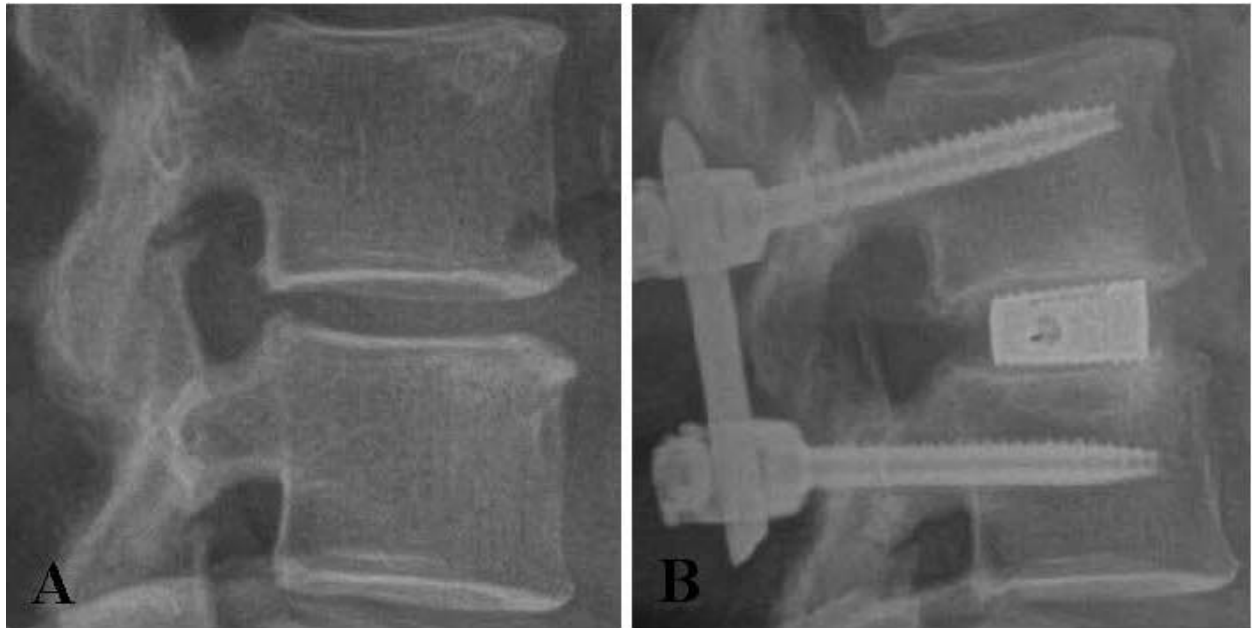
Representative (A) preoperative and (B) 12-month postoperative lateral plain film radiographic images of a 64-year-old female who underwent LLIF with an expandable interbody spacer at L4-L5.
